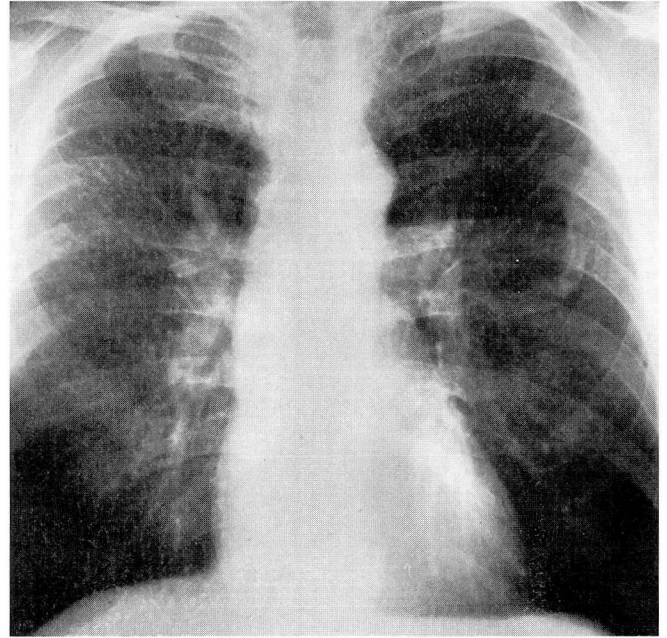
Chest radiograph showing silicosis.
